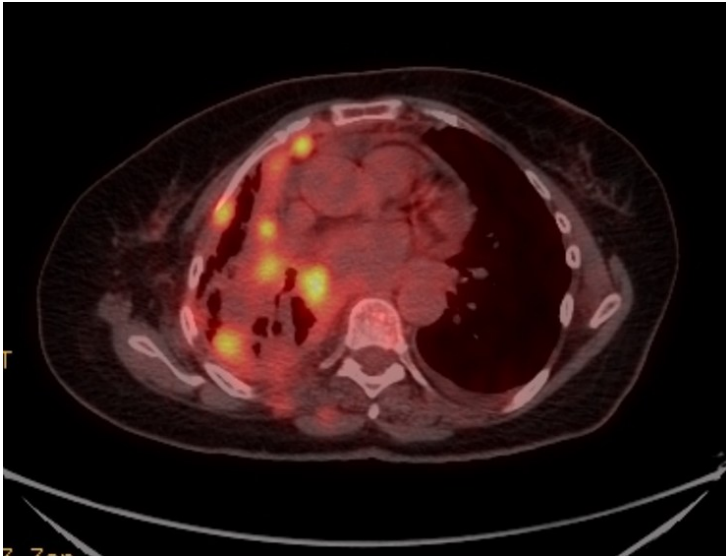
PET-CT image of a case diagnosed with mesothelioma after pleural biopsy with VATS.
